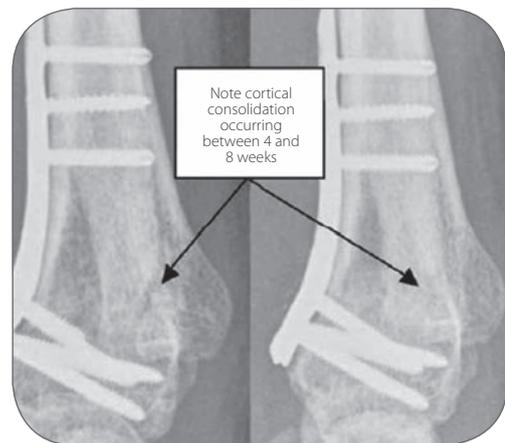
X-ray: 4 weeks post-op
